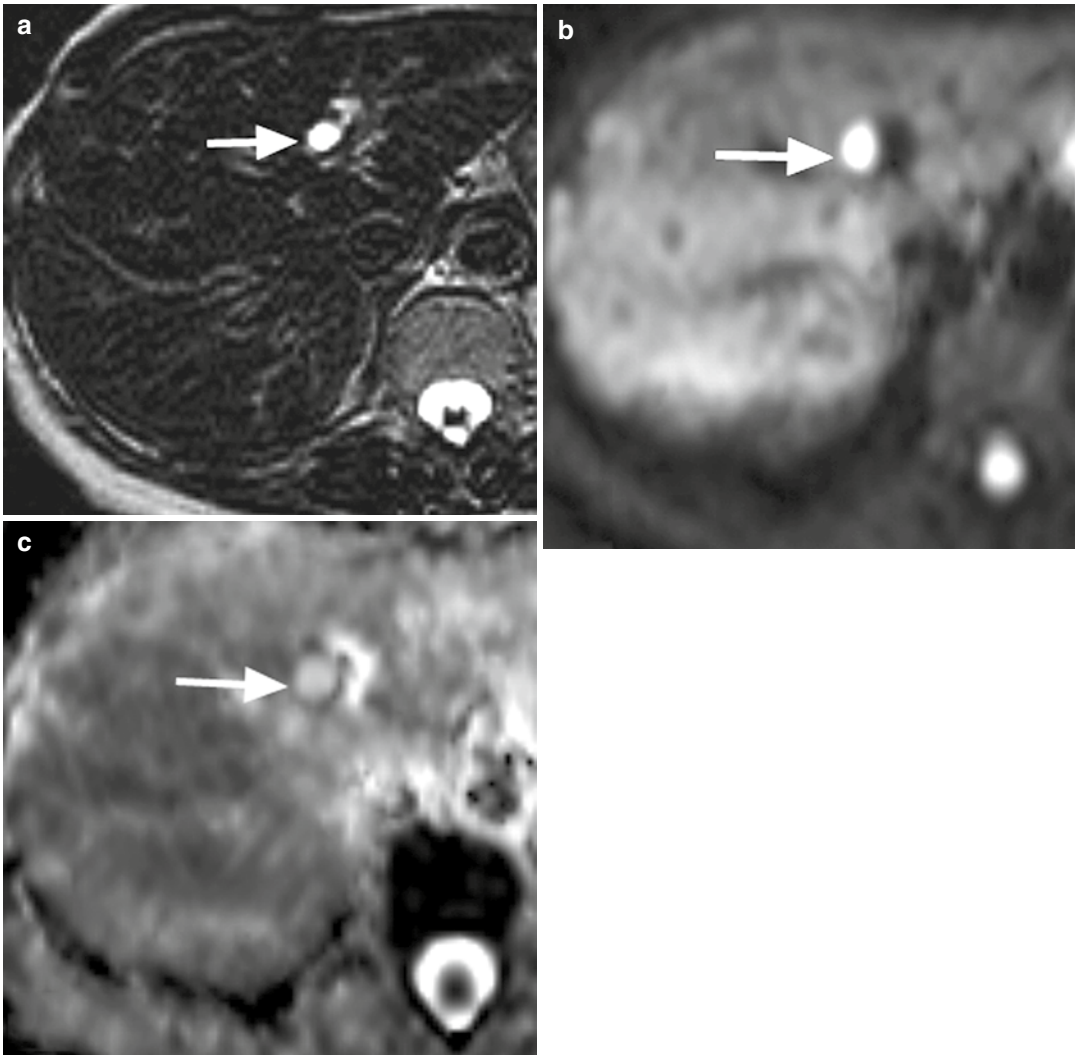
A 40-year-old man with a cyst in the left lobe of the liver. (a) T2-weighted image obtained with long echo time (TE=240 ms) shows a 1 cm high signal intensity cyst in left hepatic lobe (arrow). (b) The cyst remains
